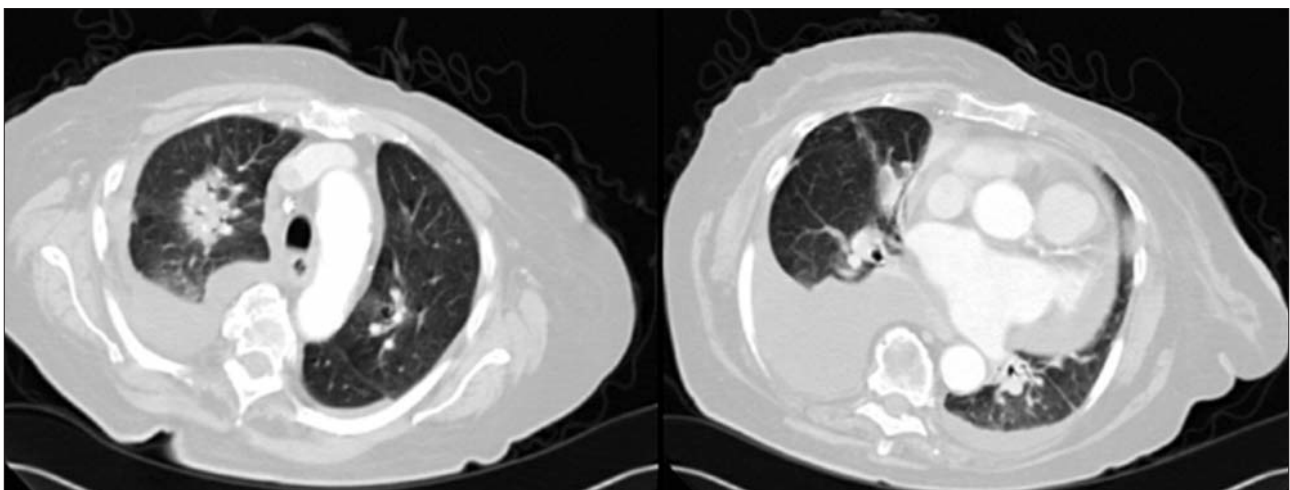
Thoracic HRCT scan: bilateral pleural and pericardial effusion, opacity in the right upper lobe.
